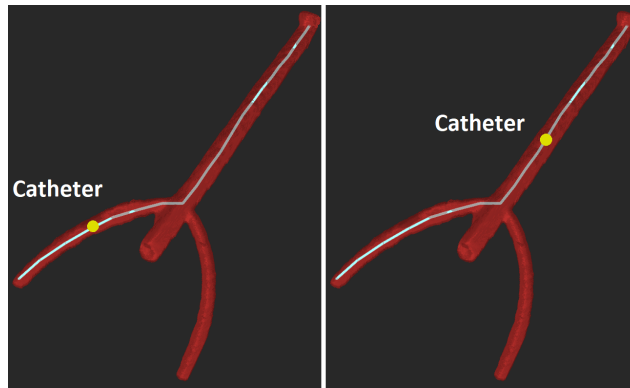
Automatic robotic catheter tracking using ultrasound, introduced by Langsch et al. [92]. The figure shows the insertion of a catheter into the aorta, with the solution maintaining the catheter tip within the ultrasound image and visualizing its position in a segmented preoperative image of the aorta.
